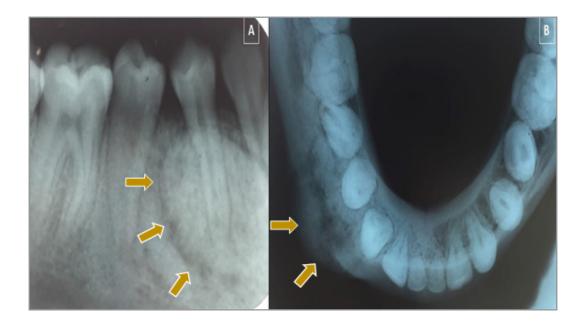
IOPA radiograph showing well-defined lesion with radiopaque central mass surrounded by a thin radiolucent rim and sclerotic border.
